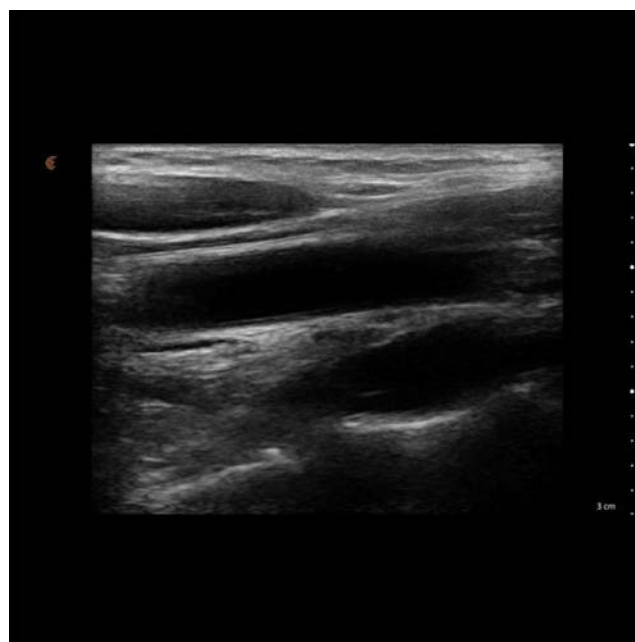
Follow-up ultrasound imaging showing resolution of vascular involvement. Post-treatment ultrasound imaging reveals improved vascular architecture with reduced wall thickening and diminished hypoechoic inflammatory changes. The previously observed cystic lesion has regressed significantly, and the vessel lumen appears more patent. Measurement shows the current vessel wall thickness to be approximately 3.0 mm, indicating a positive response to treatment. These findings suggest a reduction in inflammatory burden and improved vascular flow dynamics. Continued monitoring is recommended to assess long-term disease control and prevent recurrence.
